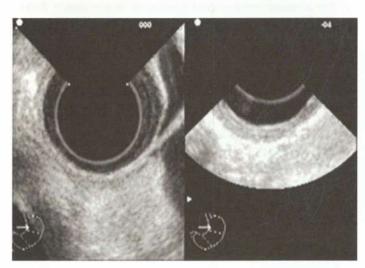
Endosonography showing oesophagus and stomach layers (*Courtesy:* Prof Ganesh Pai, HOD of Medical Gastroenterology, KMC, Manipal)
